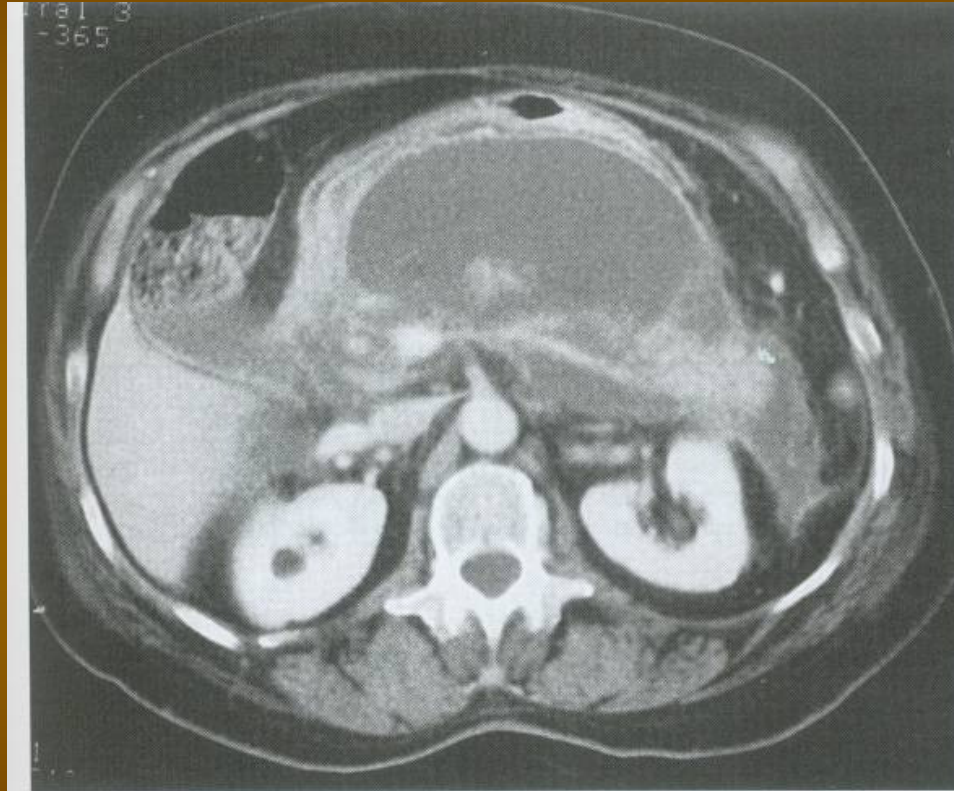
A computed tomography scan of a patient with a large retrogastric pancreatic pseudocyst. The patient had symptoms of abdominal pain, back pain, nausea, and early satiety.
